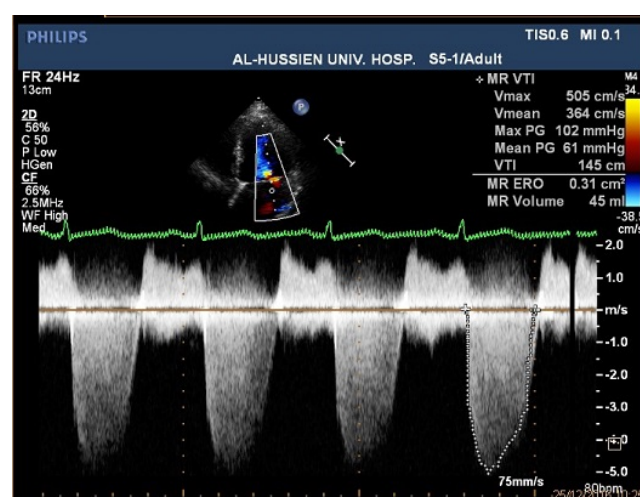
Continuous wave Doppler (CWD) of regurgitant MV.
